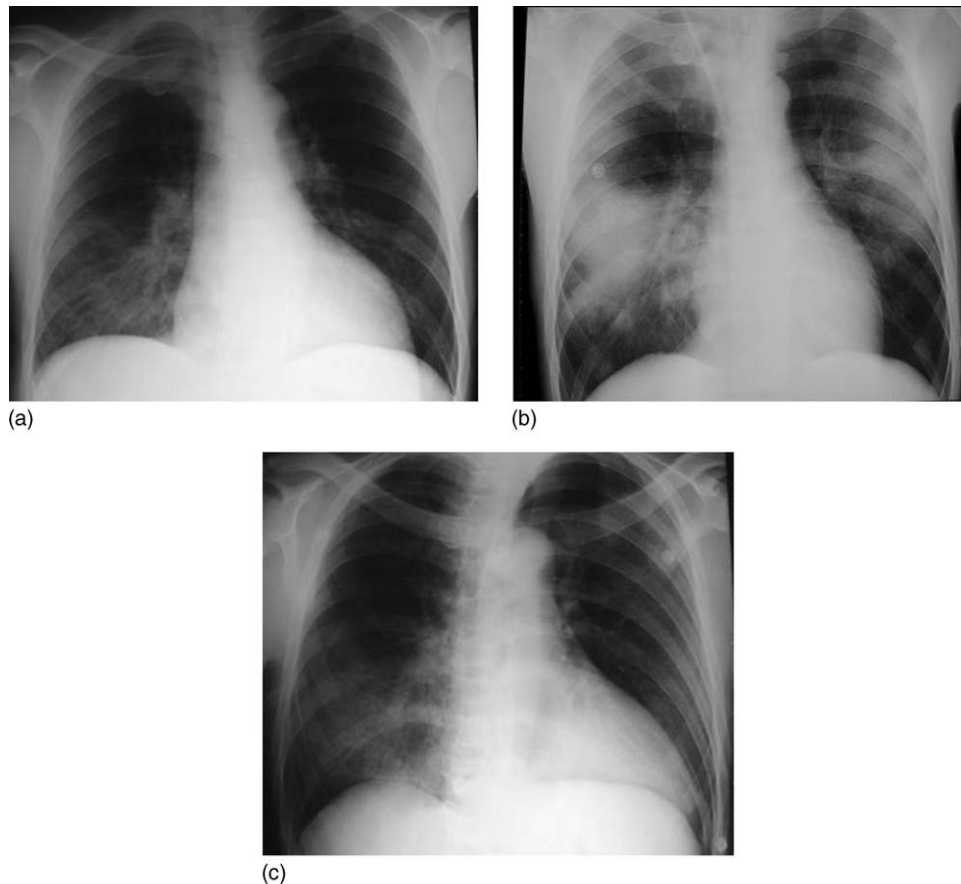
Serial chest radiographs of a 33-year-old male with severe acute respiratory syndrome who presented with fever, cough, and mild dyspnea. On day 2 of illness onset, there was mild right lower zone infiltrate (a). He developed acute respiratory distress syndrome (ARDS) on day 8 (b). Following pulsed steroid and intensive care support, there was marked improvement on day 14 (c).
